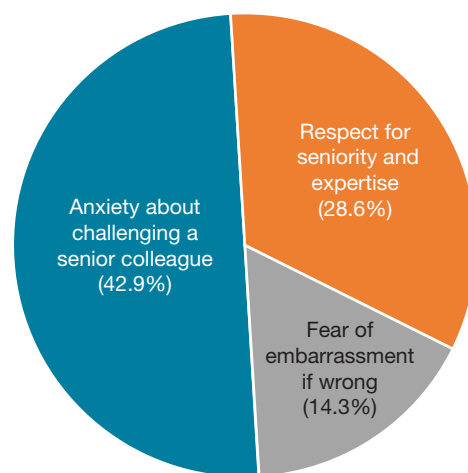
Reasons preventing junior doctors from challenging senior colleagues regarding non-indicated abdominal X-rays.
